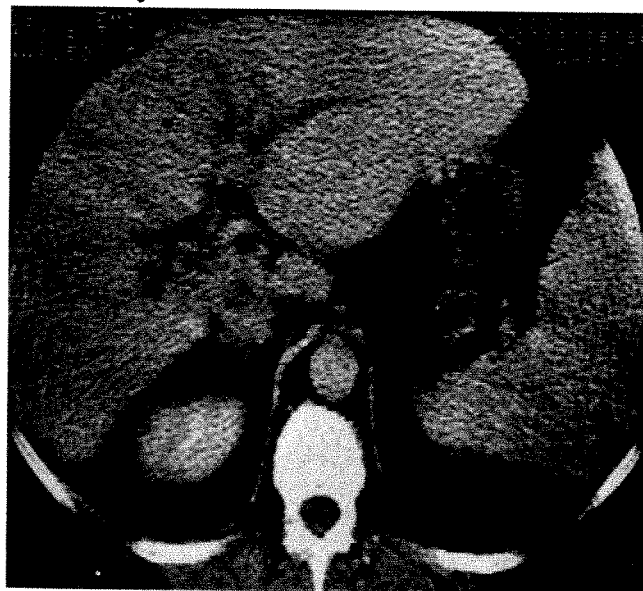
55-year-old man with malaise and pruritis; bilirubin=2.6 mg/100 ml. CT scan showing mild dilatation of intrahepatic biliary tree. Lower level scans failed to disclose dilated gallbladder, stone in distal common duct, or mass in pancreatic head, suggesting obstructing lesion proximally in biliary tract. Subsequent transhepatic cholangiography demonstrated obstruction at junction of common hepatic ducts. Surgical exploration disclosed cholangiocarcinoma.
